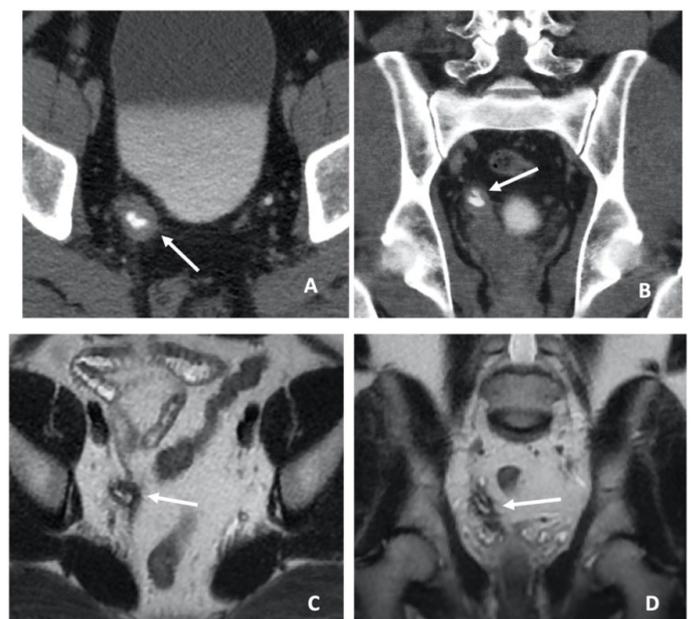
(A & B): Axial and coronal images of CT urography, excretory phase. (C & D): Axial and Coronal MRI of the abdomen & pelvis, T2-weighted images. White arrows indicate the soft tissue lesion encasing the right distal ureter with apparent intralesional ureteric dilation. Note is made of the intrinsic low T2w signal of the lesion.
